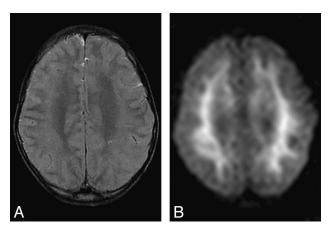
White matter DWI abnormalities. Subcortical white matter changes had corresponding positive DWI findings, which tended to closely follow the T2 signal-intensity abnormalities. The restricted diffusion was generally confluent and not associated with positive cortical DWI findings. We present 2 representative cases: an axial T2 FSE (A) and an axial EPI DWI (B) in a 7-year-old boy.
